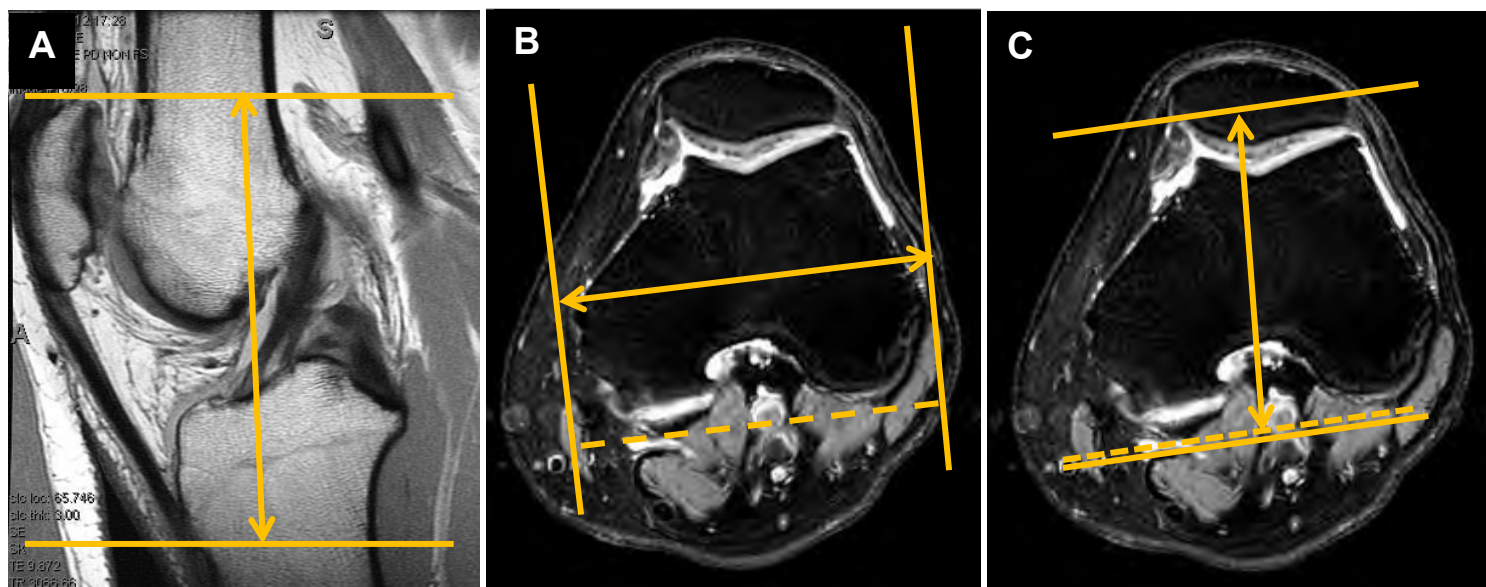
MRI of the knee. (A) Axial coverage includes the top of the patella through the patellar tendon insertion. (B) Oblique-sagittal imaging is perpendicular to the plane of the posterior femoral condyles. (C) Oblique-coronal coverage is parallel to the plane of the femoral condyles.
